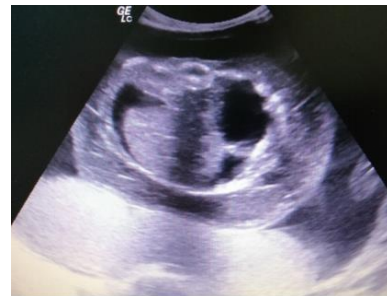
Obstetrical ultrasonography indicates fetal ascites at 24 weeks POA
